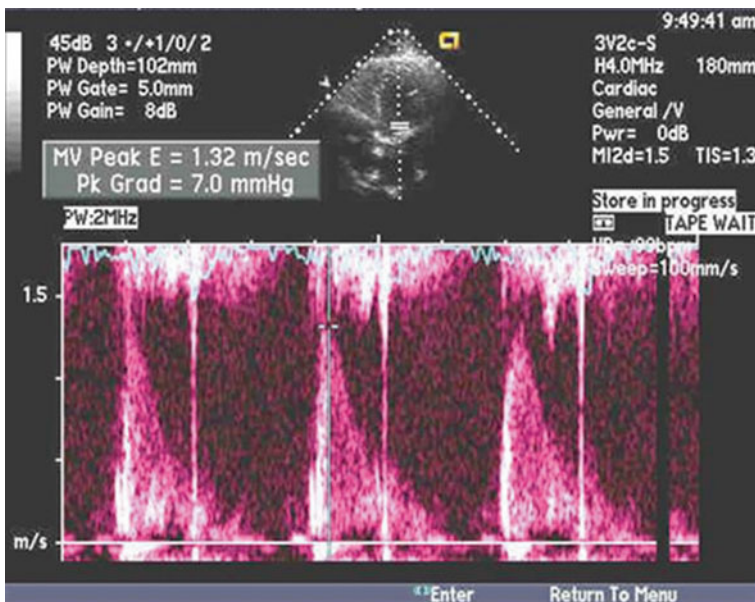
Echocardiogram of 69 year old female revealing a prosthetic mitral valve with peak velocity of 1.3 m/s
